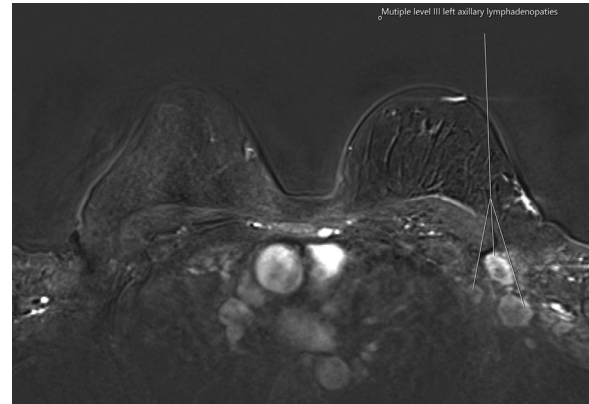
Breast MRI; Technique: Axial T1, T2, STIR, I/V dynamic images with subtraction, diffusion-weighted and T1 delayed postcontrast imaging. No suspicious abnormal enhancement is detected in either breast (both breasts MRI 1), Left multiple level III enlarged axillary nodes and left supra and infraclavicular nodes with irregular spiculated margins (MRI 6).
